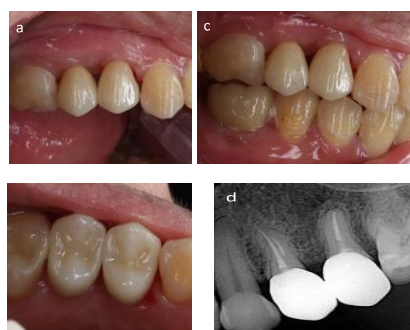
Try in crown zirconia teeth 24 and 25 a) buccal b) occlusal and palatal c) interocclusal and d) periapical radiography evaluation.
